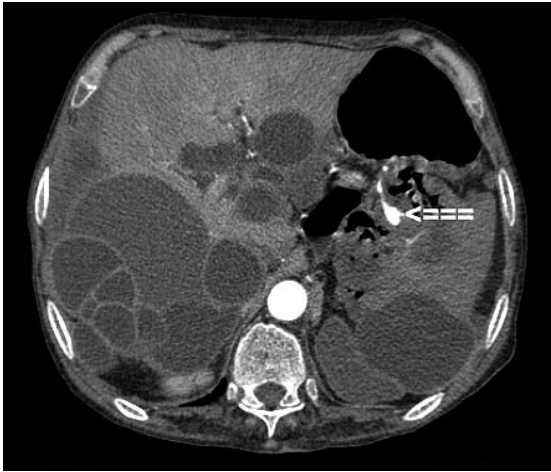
Contrast-enhanced axial CT image of the upper abdomen shows a ruptured cystic lesion measuring 5.4 cm × 5.6 cm in the inferior pole of the spleen, with an appearance of gas in the cystic cavity and an active extravasation of contrast medium at the level of splenic hilus and colon's splenic flexure (arrow). Note multiple cystic lesions in the liver and spleen.
